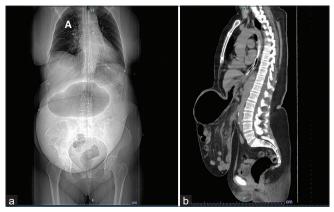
Coronal (a) and sagittal (b) views of the computed tomography scan showing a large abdominal wall hernia (45 × 45 cm) containing gastric and intestinal contents (small intestine and colon), with associated gastric distension
